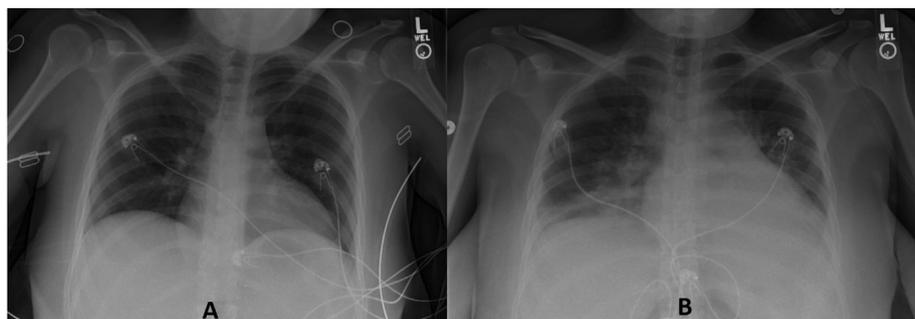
A: Initial Chest X-Ray normal findings B: Repeat Chest X-Ray showed Bilateral Alveolar infiltrates.
